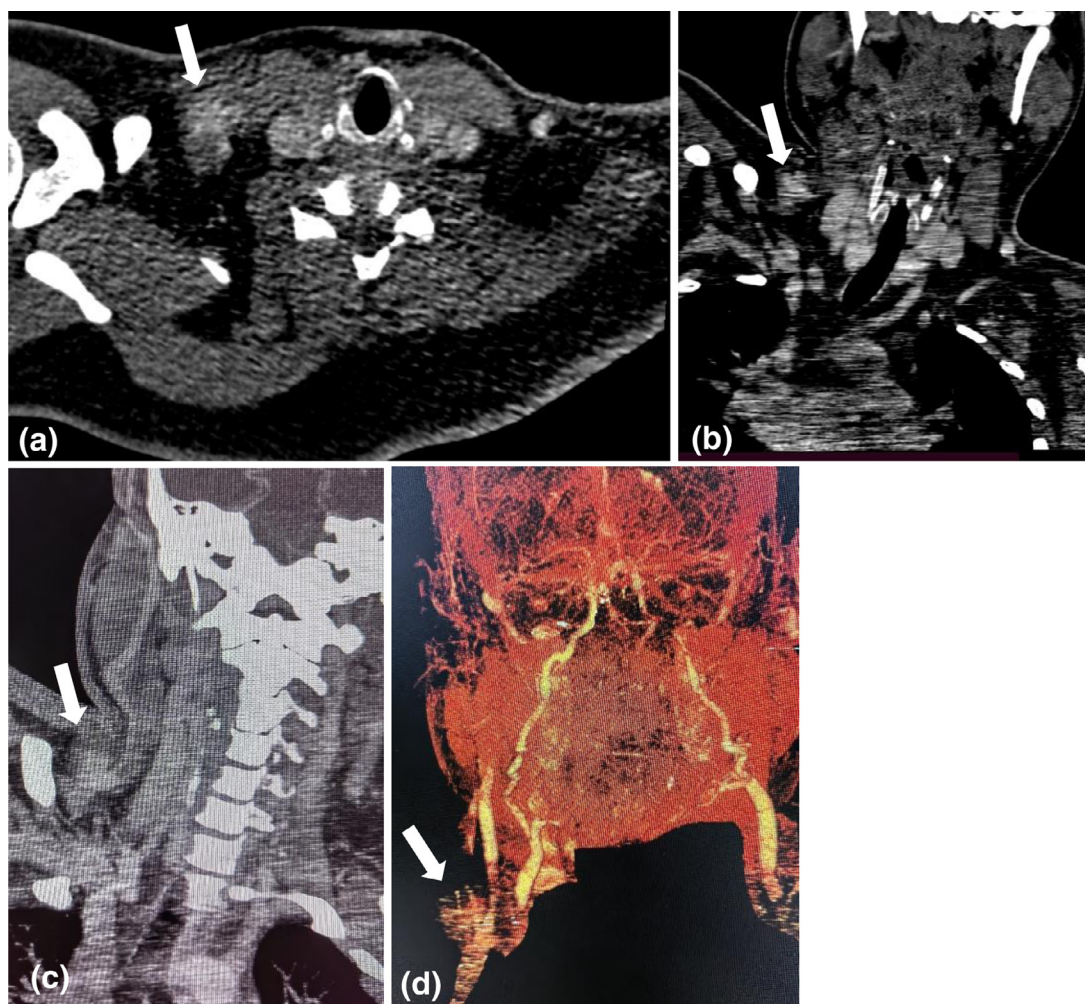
Computed tomography with contrast axial view (a), coronal (b), maximum intensity projection (MIP) reconstruction (c) and 3D reconstruction (d) of right external jugular venous pseudoaneurysm (White arrows).
